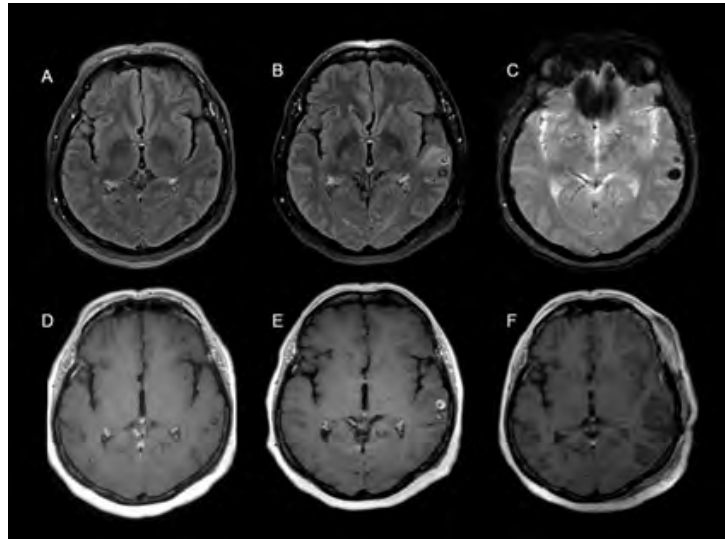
Axial brain MRI FLAIR and T1 post-contrast sequences at presentation (A and D) and eight months later on systemic ipilimumab and nivolumab for metastatic melanoma (B and E) showing new surrounding edema and contrast enhancement (CE) of the 2 superior temporal gyrus lesions. On Gradient echo (GRE) sequence the lesions were consistent with calcifications (C). Post-operative MRI (F) showing resection of both lesions.
